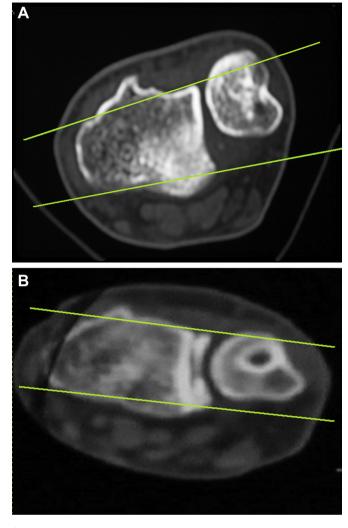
(A) Preoperative computed tomography (CT) scan shows distal radioulnar joint (DRUJ) subluxation. (B) Postoperative CT scan shows the ulnar head located between the two tracing lines that define the dorsal and palmar borders of the radius.
